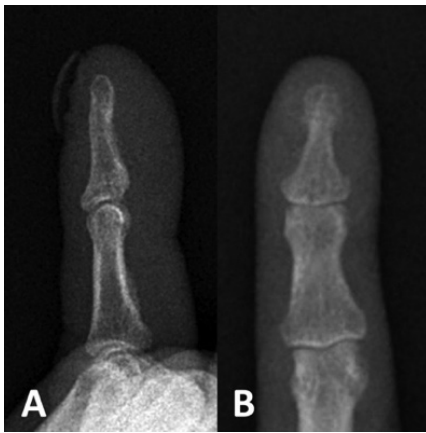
Radiography of the left fifth phalanx displays no bone involvement. (A) Lateral view. (B) Antero-posterior view
